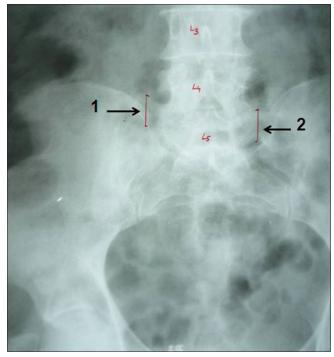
Measurements done on anteroposterior view of lumbosacral spine X-ray. 1: Width of transverse process on the right side, 2: Width of transverse process on the left side
